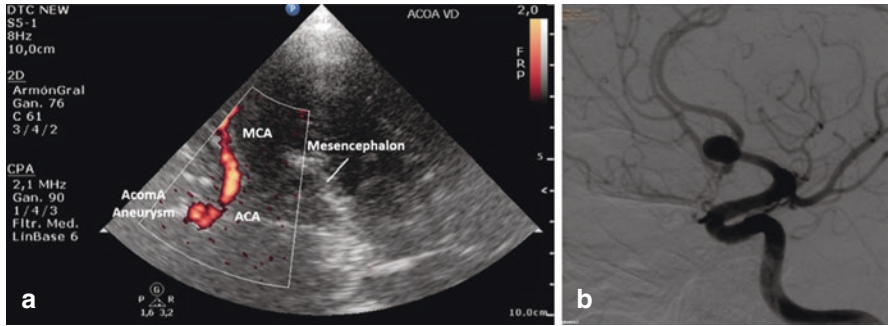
(a) TCCS: Power Doppler mode image of an anterior communicating artery aneurysm (AcomA). (b) Diagnostic arteriography of the same patient in which the AcomA aneurysm of 7 mm maximum diameter is visualized
